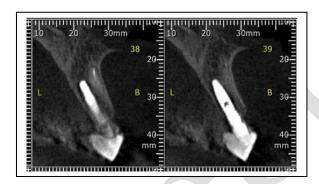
Radiographic photo showing incomplete elimination of the root apex that was attached to the labial shield.
